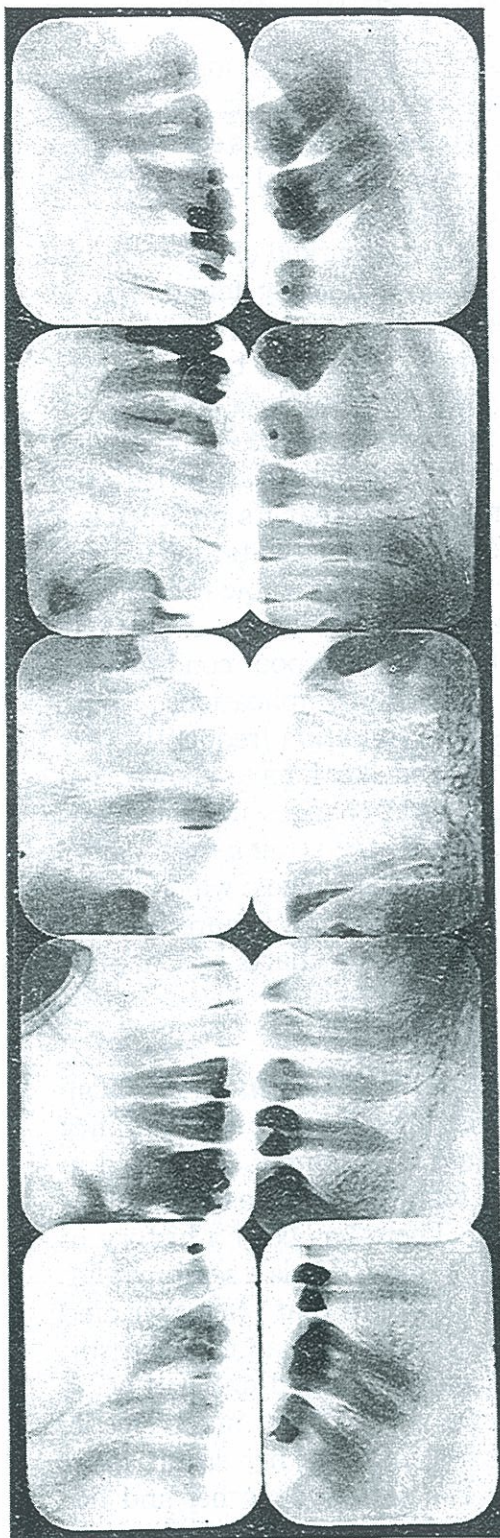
ROENTGENOGRAPHIC VIEW OF TEETH OF CASE No. 1118 WITH RECURRING HEART INVOLVEMENT.
